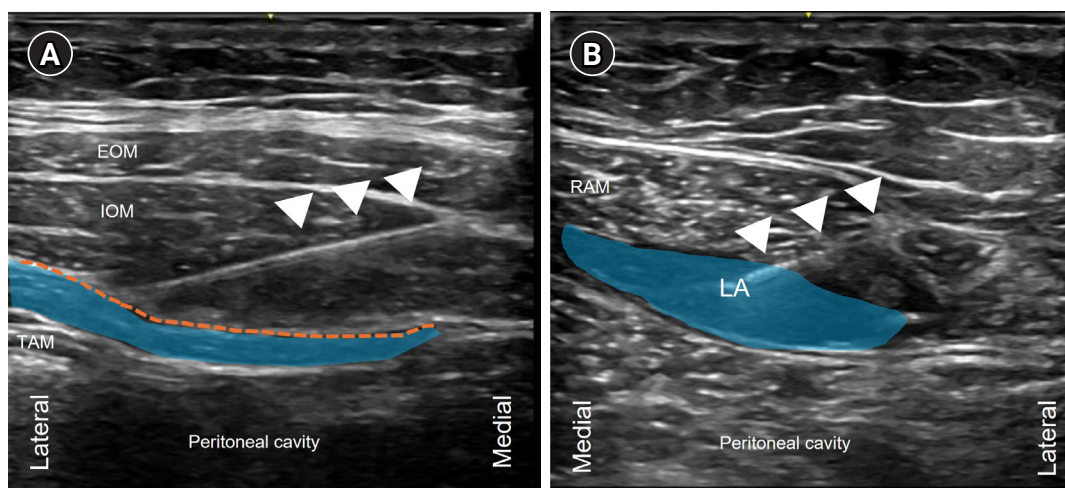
Ultrasound-guided TAP and RSB. (A) In-plane TAP block with the needle tip positioned between the IOM and TAM. The orange dashed line indicates the site of LA deposition. The LA diffused extensively into the plane between the IOM and TAM. The needle is indicated by the white arrowheads. (B) In-plane RSB at the lateral margin of the RAM, targeting the posterior rectus sheath. The needle is indicated by the white arrowheads. TAP: transversus abdominis plane, RSB: rectus sheath block, EOM: external oblique muscle, IOM: internal oblique muscle, TAM: transversus abdominis muscle, LA: local anesthetic, RAM: rectus abdominis muscle.
